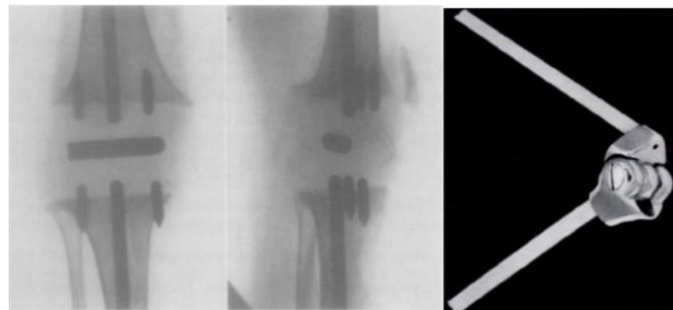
Left (X-ray) Wallidus prosthesis; right: Shiers prosthesis (27,80)
